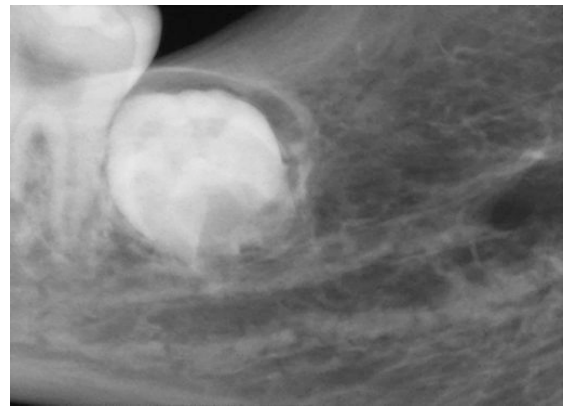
Periapical radiograph of mandibular left third molar.
